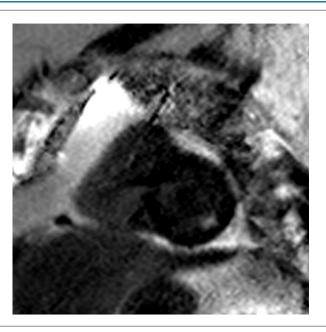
Short- axis delayed contrast-enhanced PSIR cardiac MR image, demonstrating focal subendocardial and subepicardial enhancement areas localized into the inferior and inferolateral left ventricular walls.
